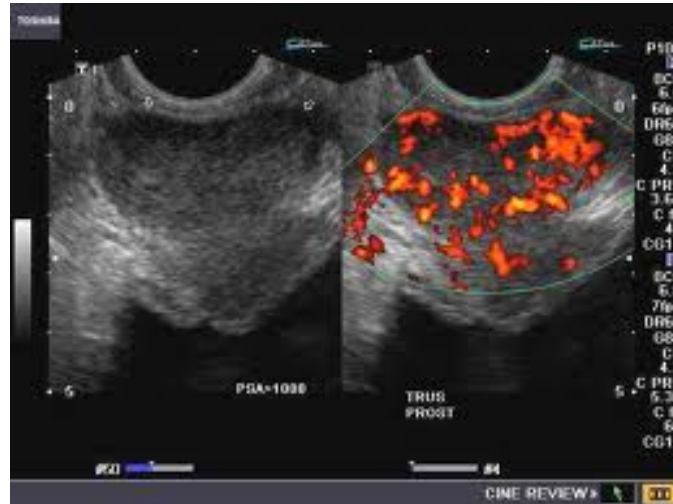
Image {2-8} : ultrasonography pf prostate cancer. I Simon, PK Landis 1999.
